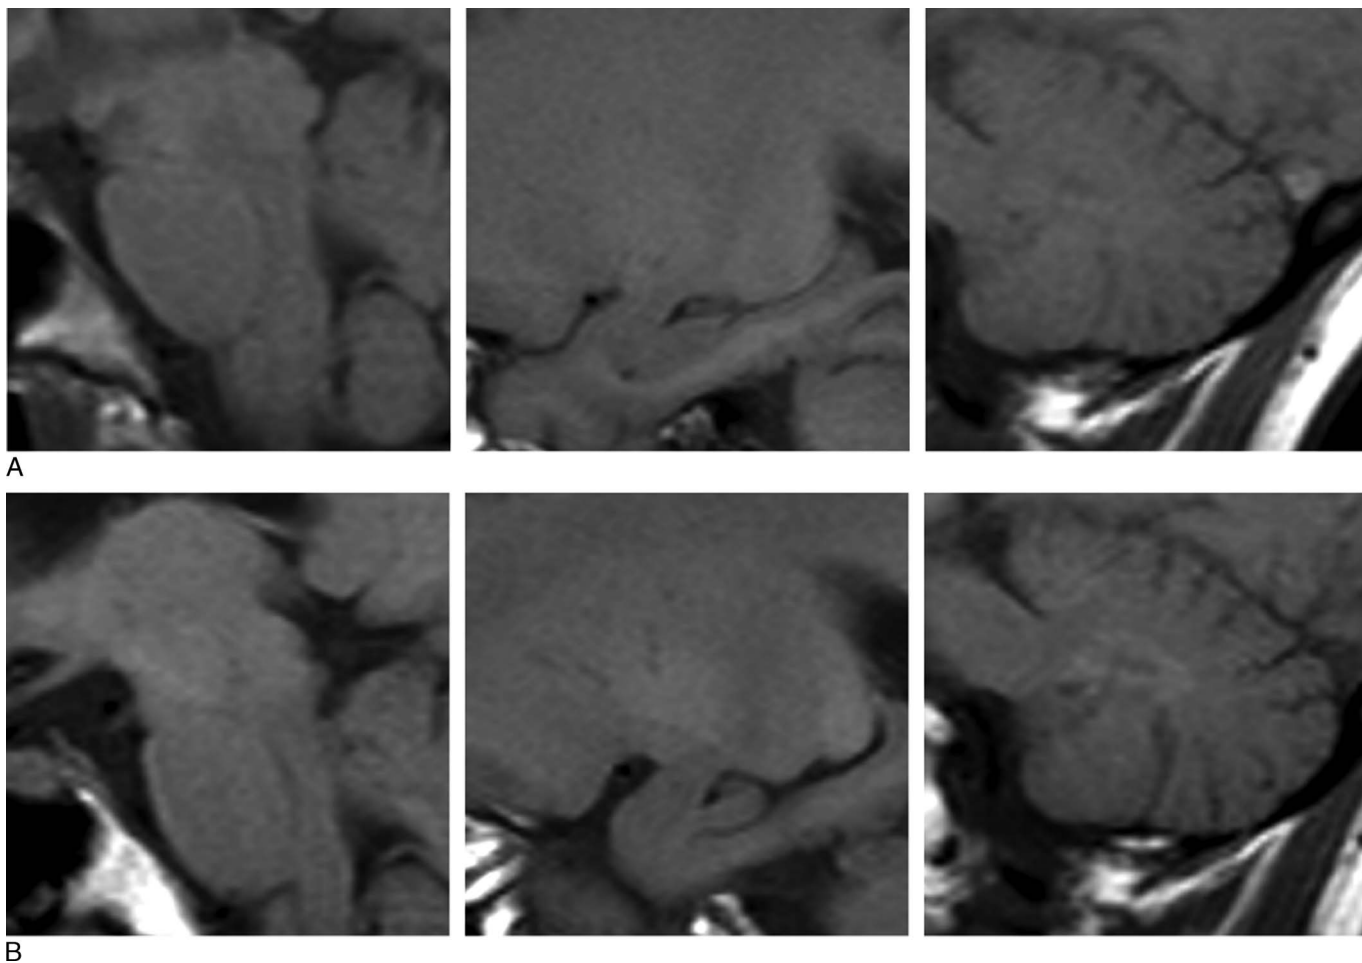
MR images of a woman experiencing right frontal glioblastoma: (A) unenhanced T1-weighted images before the first gadodiamide administration and (B) after the 10th administration showing visible increase of the signal intensity in the (from left to right) substantia nigra, colliculi, globus pallidus, pulvinar, and dentate nucleus.
